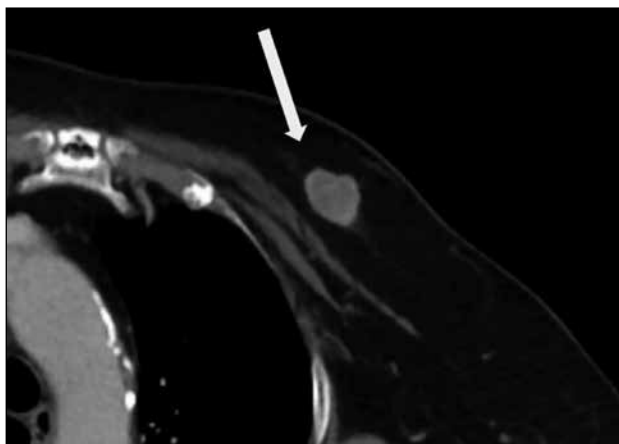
A 59-year-old woman underwent a contrast-enhanced computed tomography scan of the thorax for shortness of breath. An incidental breast mass showing peripheral enhancement is seen in the upper part of the left breast (arrow). Subsequently she underwent biopsy in the private sector that revealed invasive ductal carcinoma.
